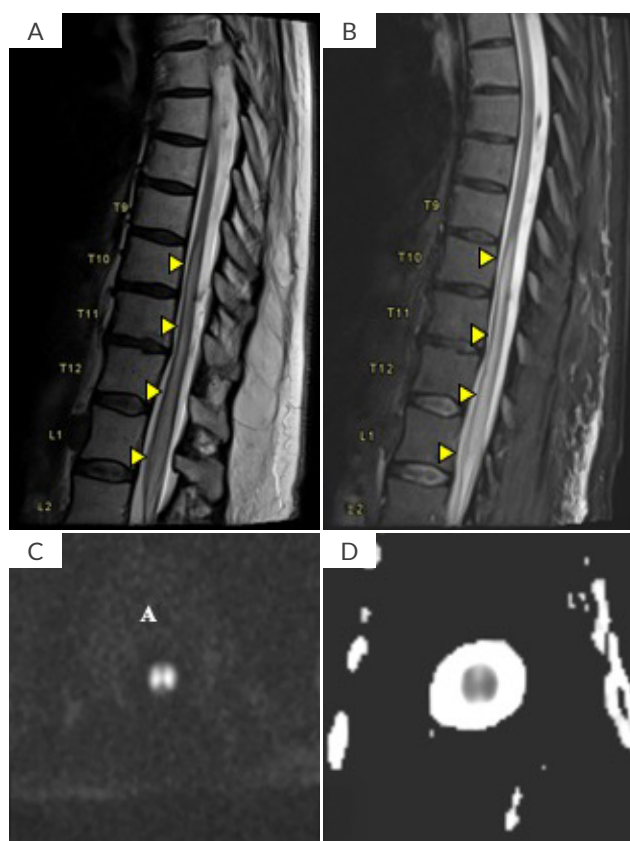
Magnetic resonance imaging of A,B) the spinal cord demonstrates long segment oedema of the distal third of the spinal cord, best seen on sagittal T2-weighted turbo spin echo sequence and on sagittal turbo inversion recovery magnitude sequence (arrow ◀) with "H-shaped" high signal intensity on diffusion weighted images and low values on an apparent diffusion coefficient map ("diffusion restriction") which is consistent with acute ischemic infarction of gray matter of the spinal cord.
